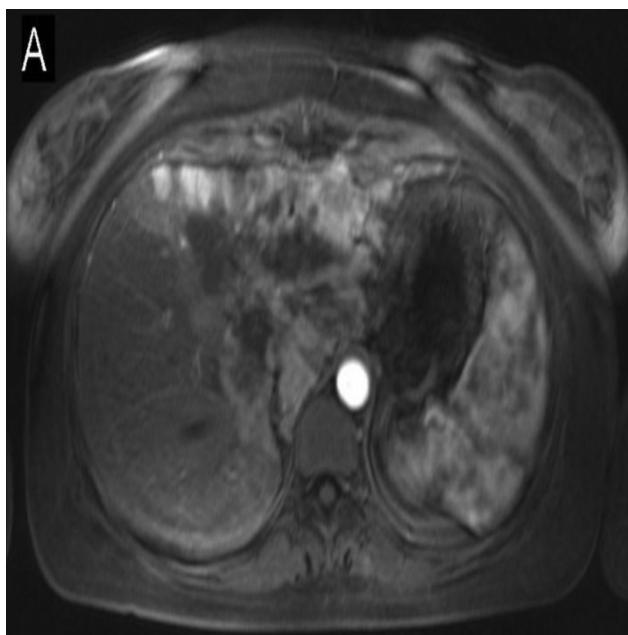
Magnetic resonance imaging showing gross, hypervascular lesion with diffuse infiltrating character and not well-defined borders.
